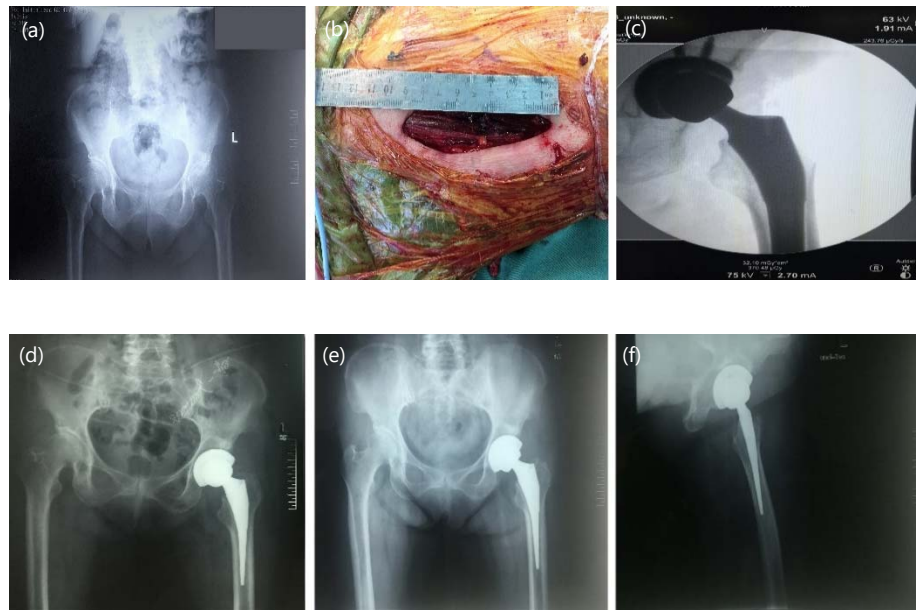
(a-f): Radiographs of a 68 years-old female patient with avascular femoral head necrosis of the left hip, (a) Plain radiograph of the pelvis before surgery, (b) Intraoperative photograph of the incised fascia of the TFL, (c) View of the Acetabular cup through the c-arm, (d) Postoperative AP plain radiograph showing the successful of THA-DAA. Postoperative, (e) AP and (f) Med-lateral plain radiographs during the 3-months follow up after surgery
